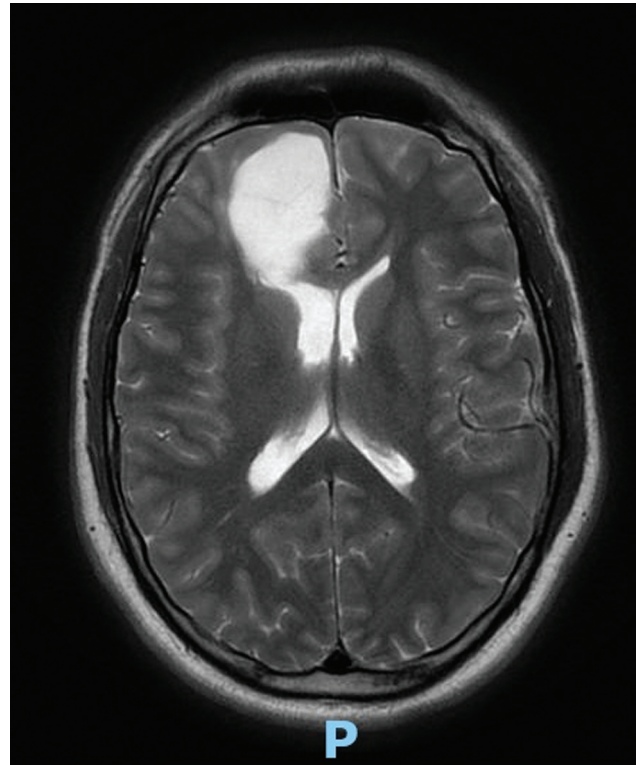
Axial magnetic resonance imaging (MRI) scan showing an expansive fronto-basal tumor.
